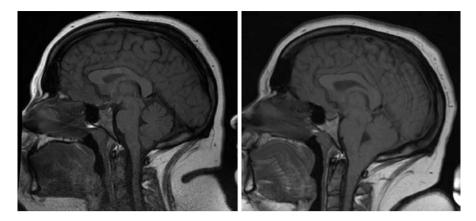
Patient developed low cerebrospinal fluid (CSF) tension symptoms 9 years after placement of a lumboperitoneal shunt for treatment of idiopathic intracranial hypertension. Comparison of magnetic resonance imaging scans from prior to shunt placement to onset of positional headache symptoms identifies changes of CSF hypotension including pituitary enlargement, optic chiasm flattening, tonsillar herniation, decreased mamillopontine distance, and a decreased pontomesencephalic angle
